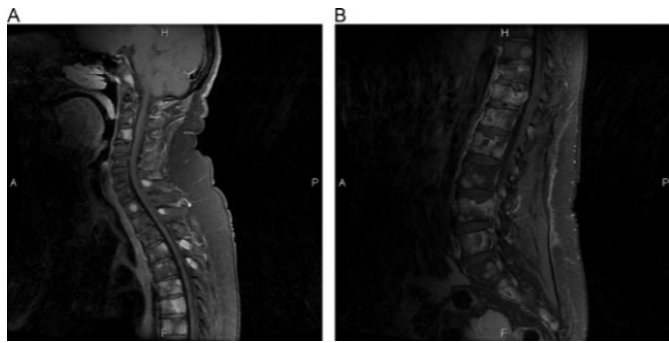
A cervical and lumbar spine MRI image
